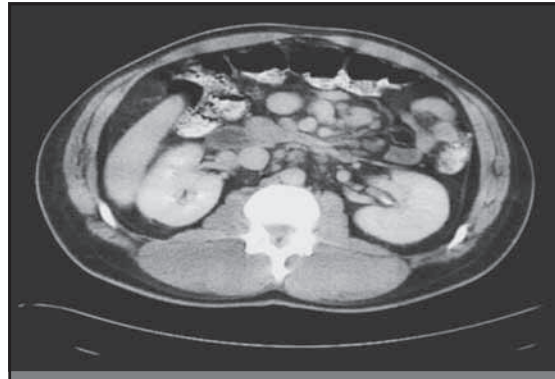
Abdominal CT scan that demonstrates prominent, symptomatic intra-abdominal lymphadenopathy in a patient who developed the immune reconstitution inflammatory syndrome in association with disseminated *Mycobacterium avium* complex infection.
